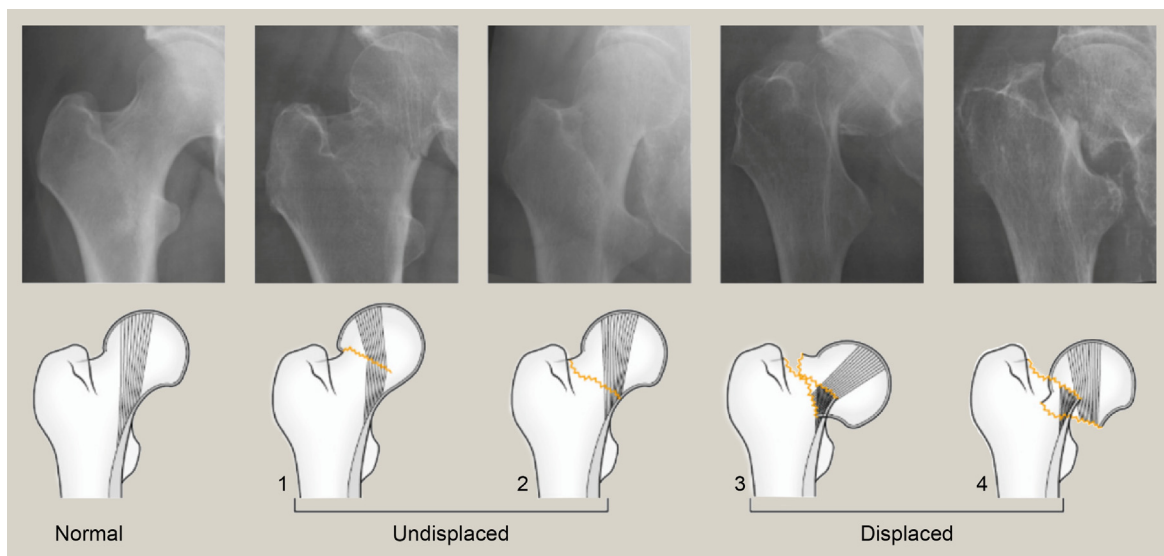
Garden classification of intracapsular fractures. Garden 1: The fracture is *valgus* impacted (i.e. the apex of the fracture points medially). Classically, the medial cortical fracture is not seen on the radiograph. Garden 2: The fracture is complete but *undisplaced*, but the trabeculae remain aligned. Garden 3: The fracture is moderately displaced with disturbance of the trabecular pattern. Garden 4: The fracture is displaced but the trabeculae line up to indicate the head is in a neutral position. Reproduced from McRae's Orthopaedic Trauma 3rd ed. by White TO et al, with permission.
